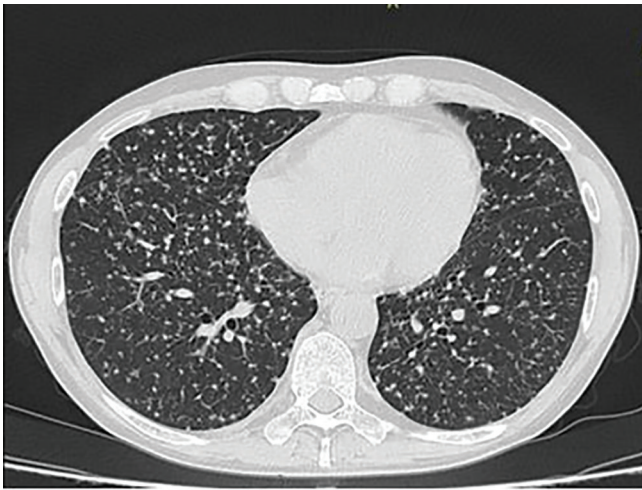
Thoracic CT axial lung window with bilaterally disseminated pulmonary micronodules.
